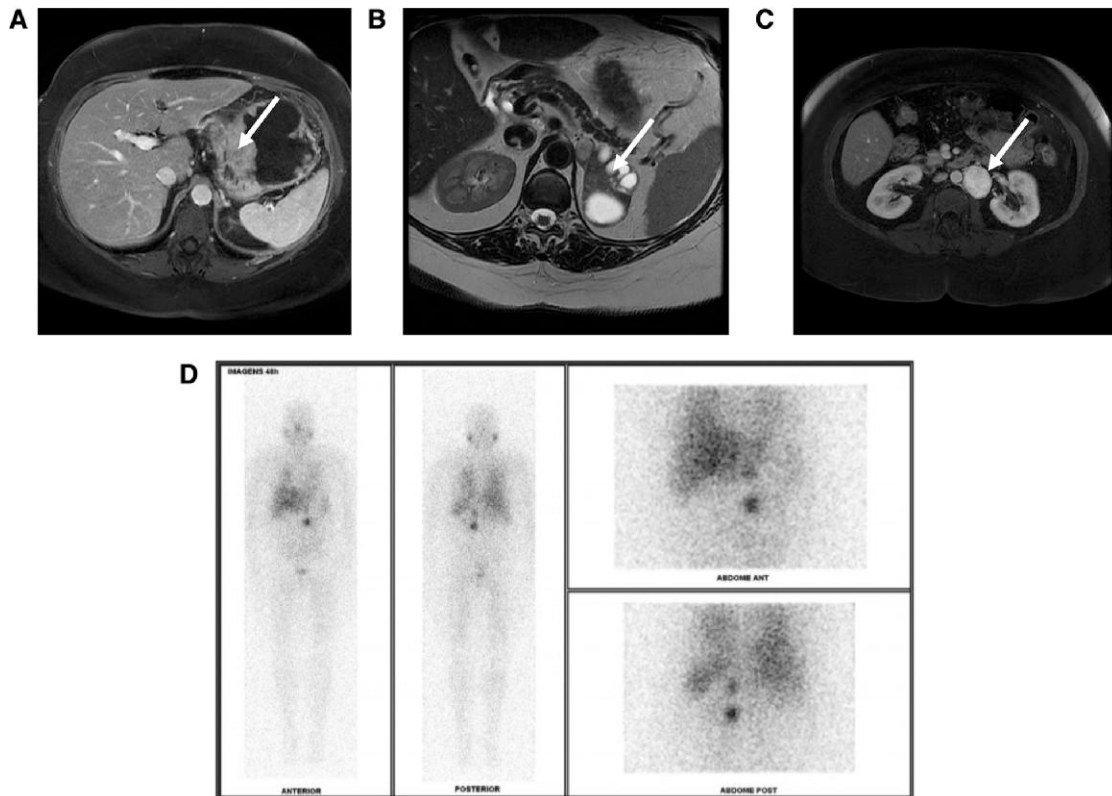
(A) Magnetic resonance imaging (MRI) scan showing a 10-cm GIST with apparent origin in the gastric body and fundus (white arrow). (B) Axial T₂-weighted MRI showing a 7-cm left solid cystic pheochromocytoma (white arrow). (C) Axial T₂-weighted MRI indicating 4-cm para-aortic paraganglioma (white arrow). (D) Meta-iodine-benzyl-guanidine labeled with iodine 131 (¹³¹I-MIBG) scan demonstrating a high uptake in the left para-aortic and adrenal lesions. GIST, gastrointestinal stromal tumor.
